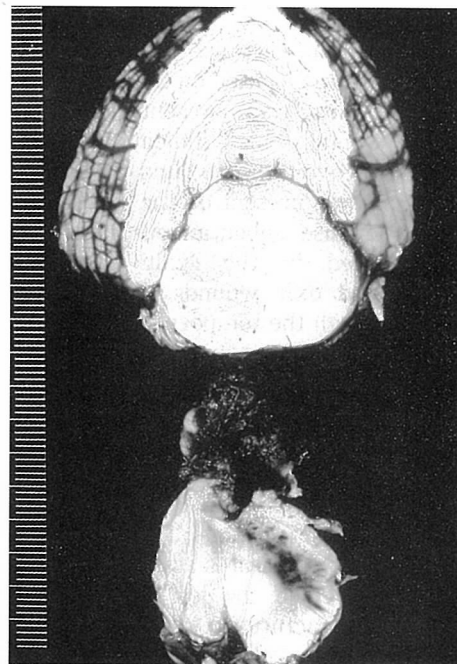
The findings of the midbrain. A hemorrhage is in the left midbrain, which was not demonstrated in the CT-scan.
